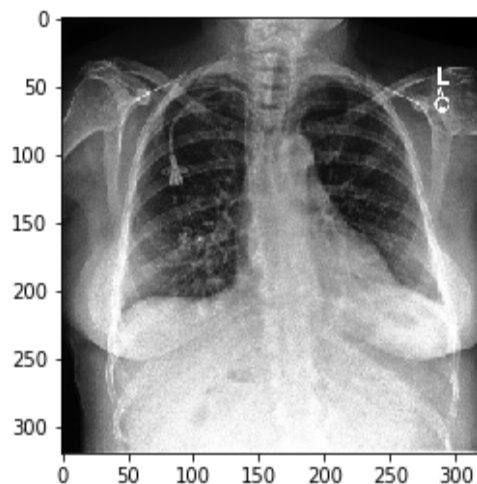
Example of a Chest X-ray Image Showing Pneumonia Affliction
